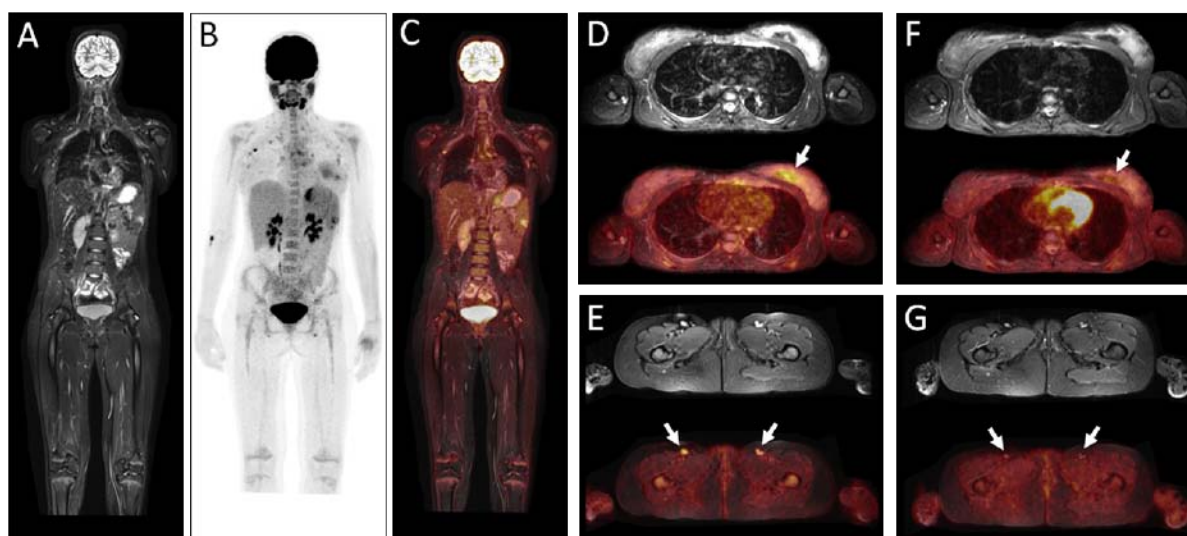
14 year old female patient that was diagnosed with acute myeloid leukemia (AML). Primary staging with integrated PET/MR (A-C) revealed renal, pancreatic, mammary, splenic, and lymph node involvement. Chemotherapy was thus commenced. PET/MR imaging at 1 months follow-up after start of chemotherapy (D,E) revealed residual tumor in left mammary formation ($SUV_{max} = 3.6$) (arrow in D) and residual tumor in inguinal lymph nodes ($SUV_{max} = 3.1$) (arrows in E). PET/MR imaging at 2 months follow-up after start of chemotherapy (F,G) shows a complete response to chemotherapy and no sign of increased tracer activity in the same regions (arrows in F,G). Courtesy of Dept. of Nucl. Medicine (Director: Prof. Dr. O. Sabri), University of Leipzig, Germany.
